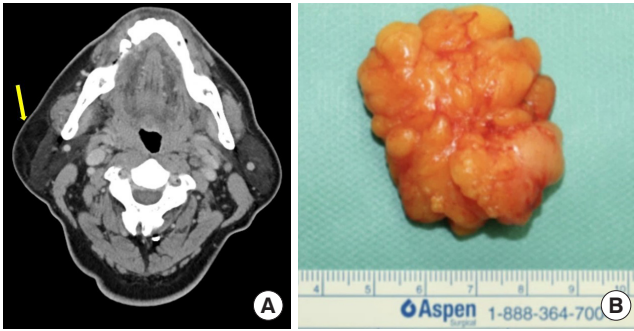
Discrepancy between the actual depth of the facial lipoma and the predictive depth of the preoperative diagnosis. (A) Preoperative computed tomography finding: about 3.4×1.5×4 cm sized well-defined nonenhanced fat-attenuated mass at right parotid space, peri-parotid subcutaneous fat layer, suggesting lipoma (arrow). (B) The record of the operative note: 4×5 cm round-oval, soft, movable mass, attached to the parotid-masseteric fascia from the subplatysmal muscle in the right mandibular angle area.
